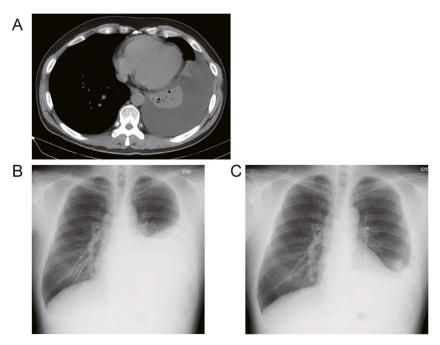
Improvement of the massive left pleural effusion on plain chest radiographic images
